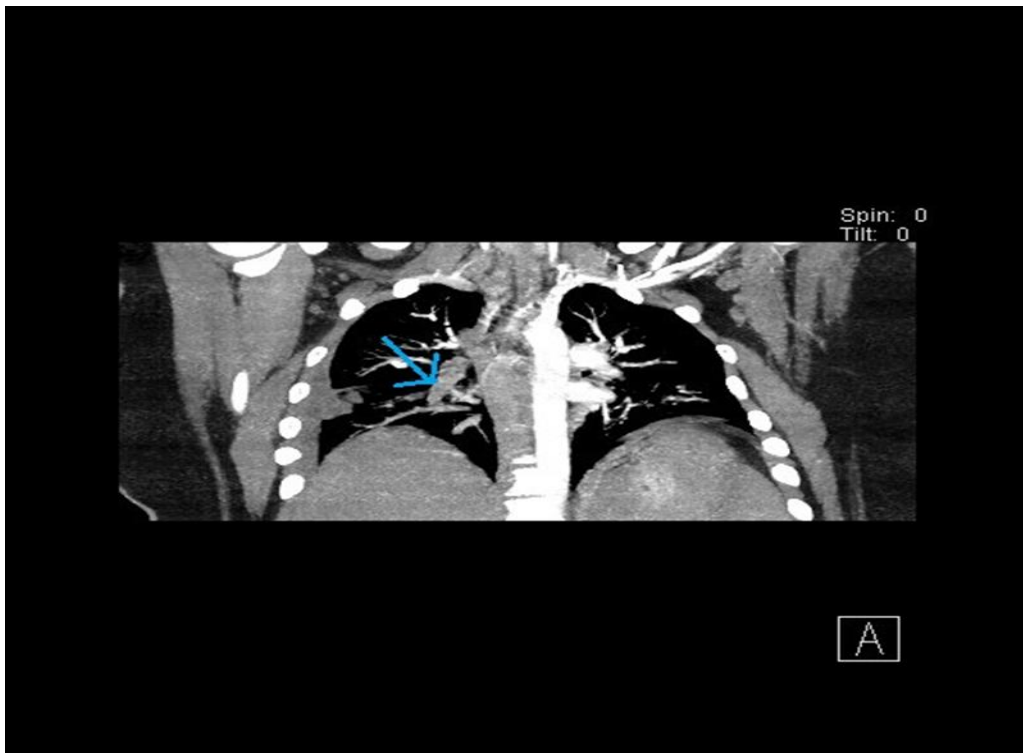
CT PULMONARY ANGIOGRAM coronal and axial MIP views showing occlusion of the inferior division of the right pulmonary artery (blue arrow) impressive of acute pulmonary embolism.
